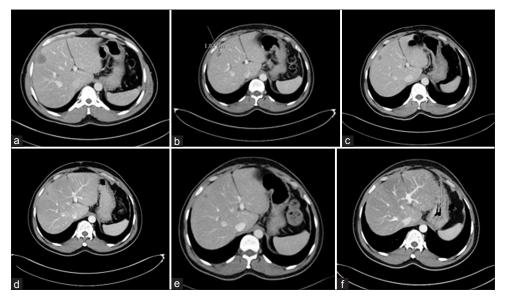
Serial computed tomography (a) metastatic liver lesion just before starting octreotide-LAR therapy in October 2011 (b-f) Subsequent computed tomography images over 82 months demonstrating continuous and maintained response. (b) August 2013, (c) August 2014, (d) August 2016, (e) July 2017, (f) August 2018
